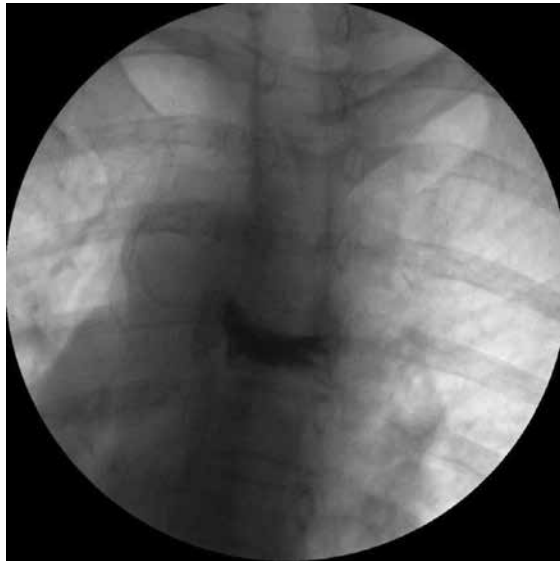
AP radiograph after PMMA injectate.
